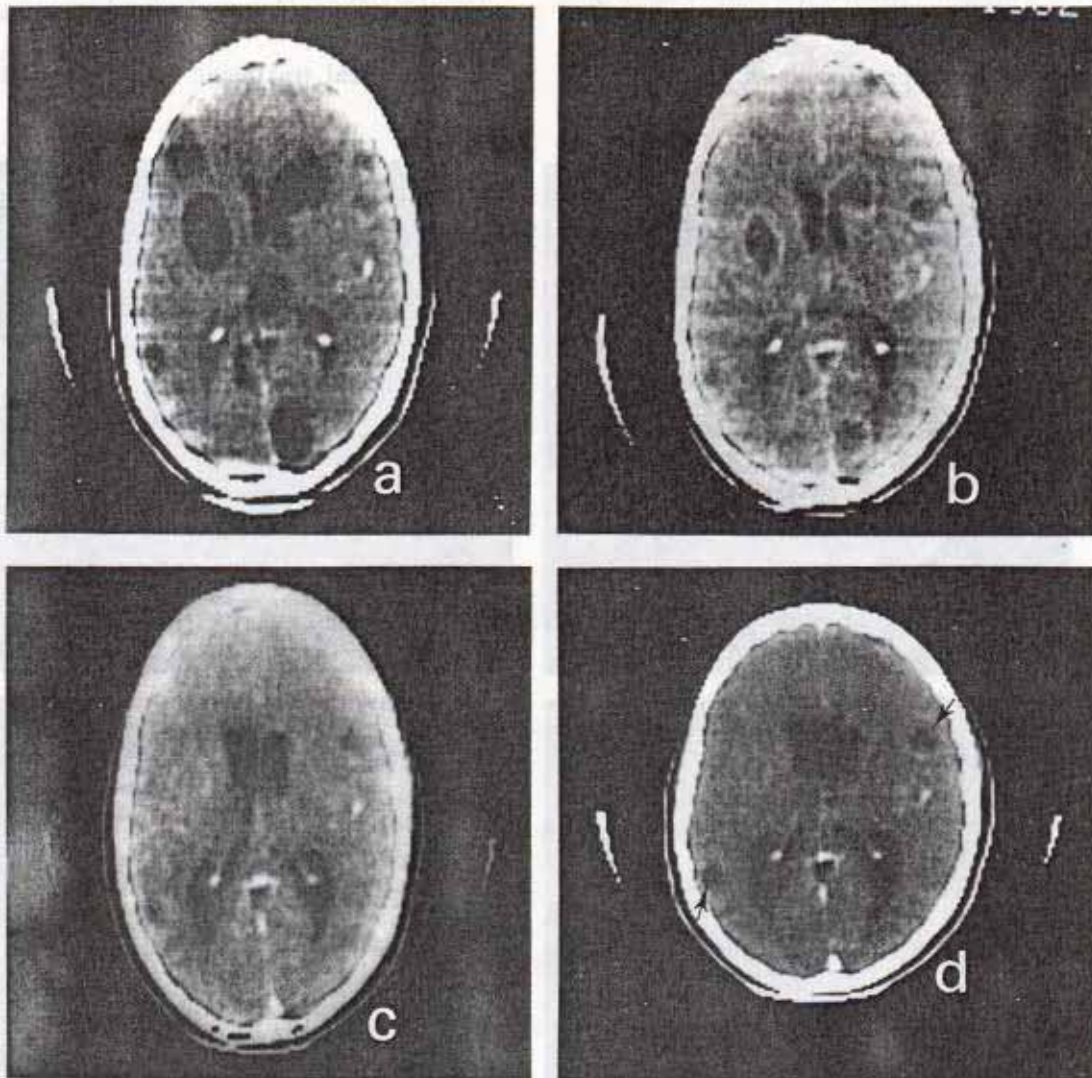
Contrast CT Scans before and after Praziquantel Therapy in a Patient with Macroscopic Cysticercus (Patient 7, Table 1).
